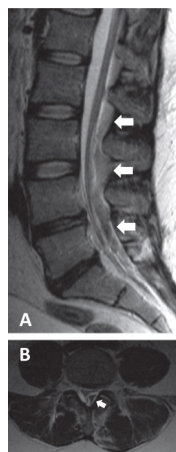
(A) MRI lumbar spine: sagittal view. There is a marked mass effect from epidural blood, with severe canal stenosis and complete effacement of the cerebrospinal fluid (CSF) at L4–5. (B) MRI lumbar spine: axial view. Blood is asymmetrically left sided, with mass effect on the thecal sac, causing complete effacement of the CSF and compromising the left L5 nerve root in the lateral recess (adapted from Yi *et al*¹⁴ with permission).
